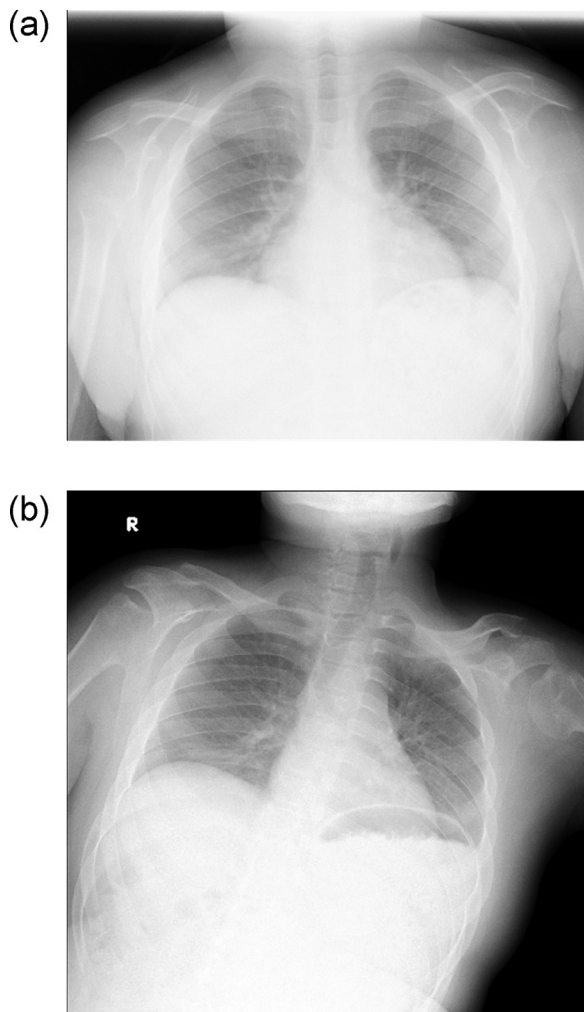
(A) A chest radiograph showing bilateral hypertrophy in the ribs and clavicles at 9 years of age. (B) A follow-up chest radiograph at 17 years of age showing that the findings did not progress.
